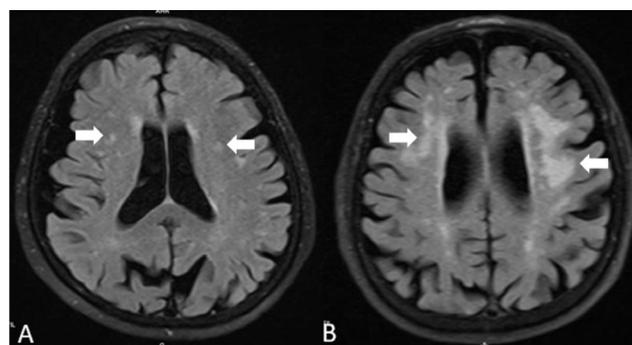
Axial FLAIR MR images showed A); Fazekas grade 1 WMHI (white arrows), grade 3, B) WMHI (white arrows)
